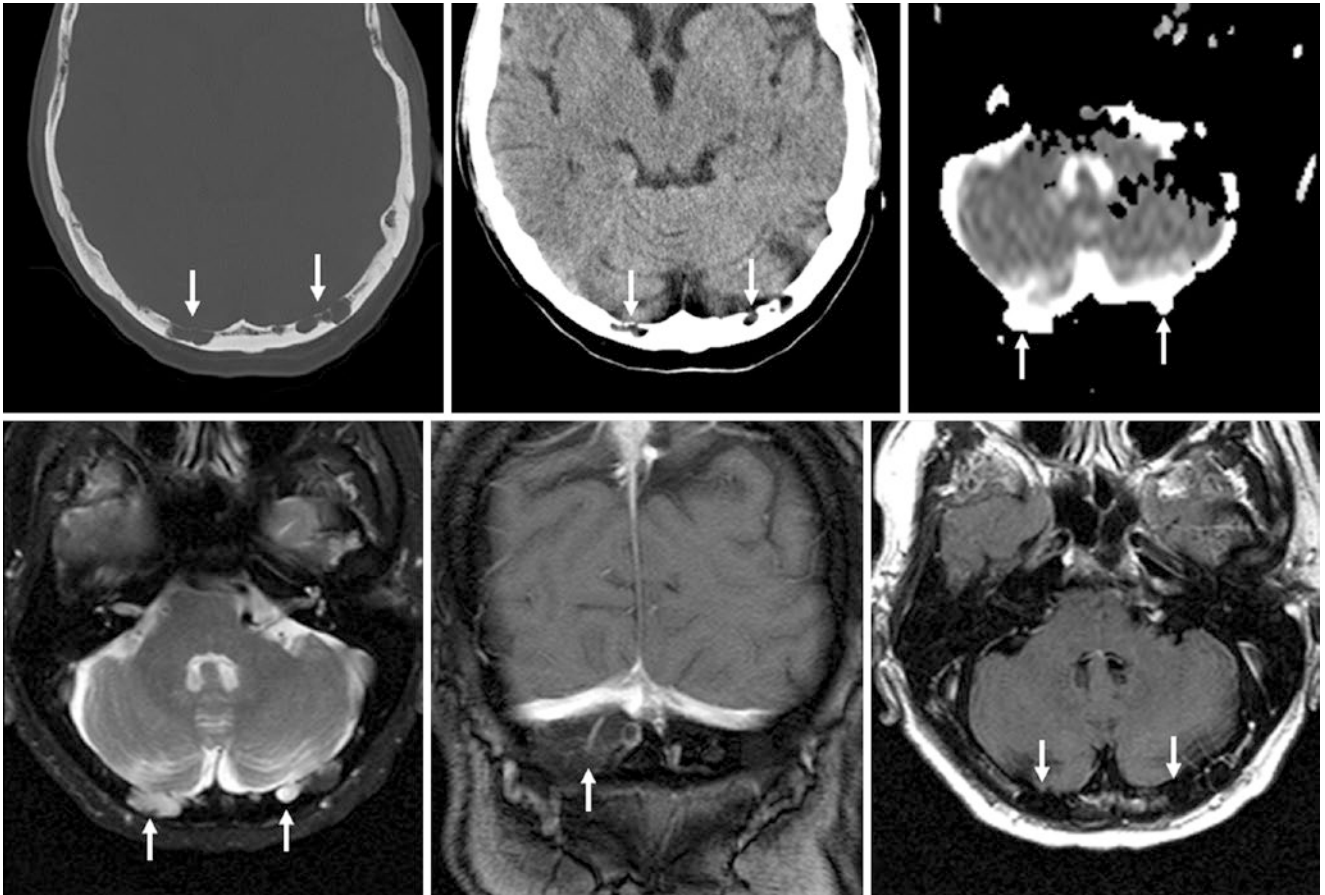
A 75 year old with prostate cancer who had irregular pacchionian granulations of the occipital bone on NECT (*top left and middle*). These resembled CSF on ADC map (*top right*) and T2WI (*bottom left*) and did not enhance on T1WI (*bottom middle*) or FLAIR (*bottom right*)
